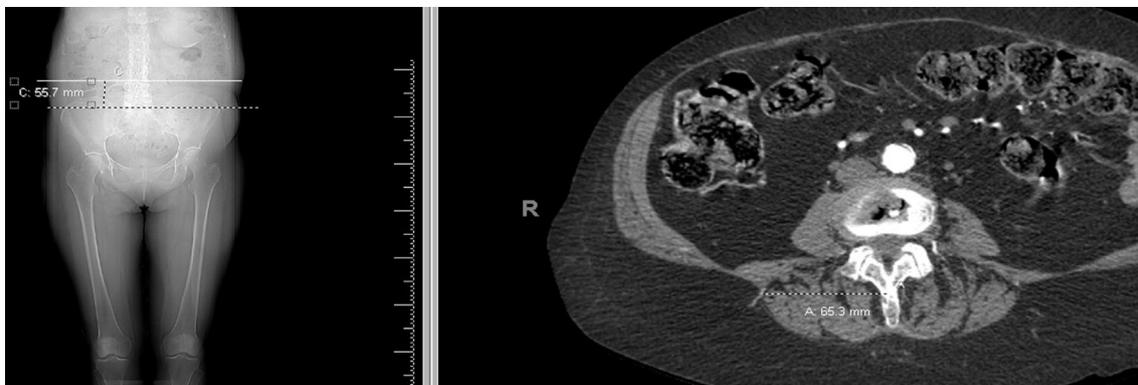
An axial CTA abdomen image is linked with the scout image to determine the PSIS distance. The midline distance is also measured on the axial image.
